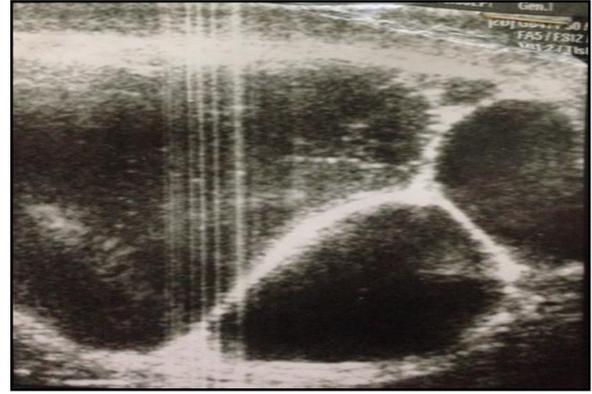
Ultrasound view of left multilocular spermatocele
